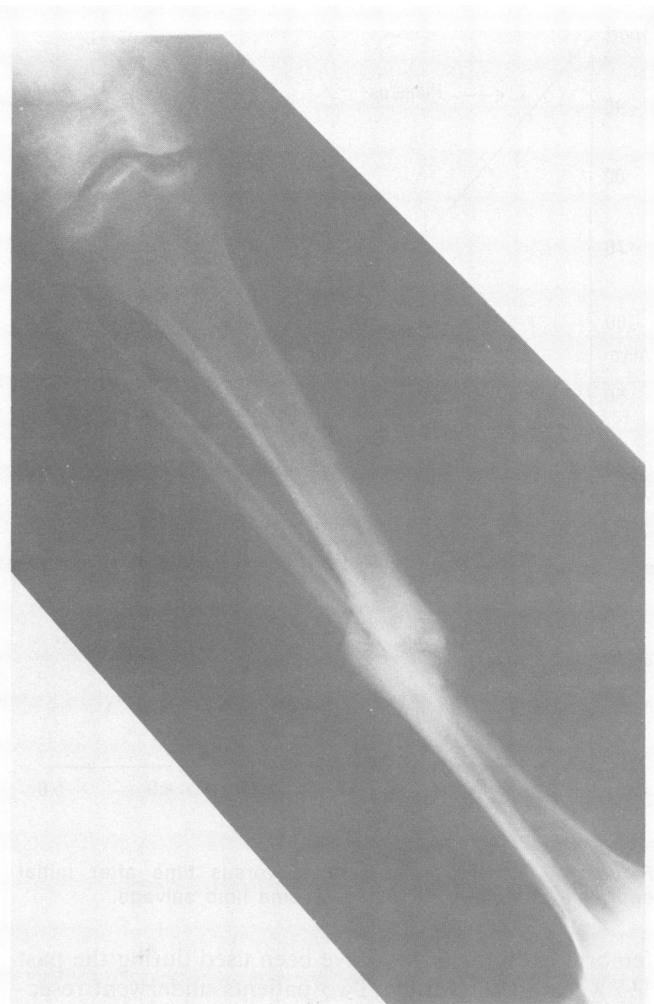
X-ray examination 19 months postfracture shows nonunion of tibia, with hypertrophic callous formation and varus deformity.
